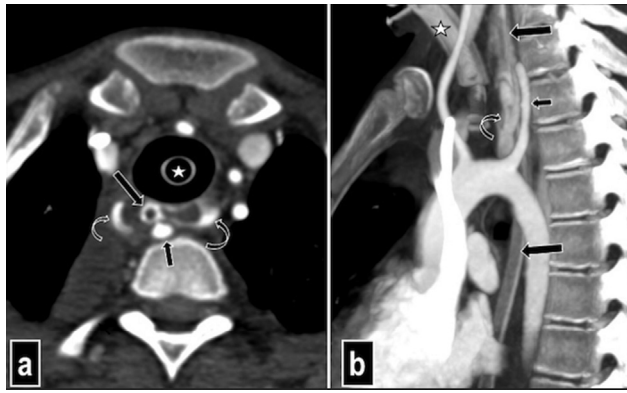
(a) Axial and (b) sagittal CT angiography images showing the retroesophageal aberrant right subclavian artery (small arrows). Nasogastric tube (larger arrows) and tracheostomy tube with bulb (asterisk) is seen in situ. There is contrast extravasation into the esophagus (curved arrows). CT, computed tomography.
